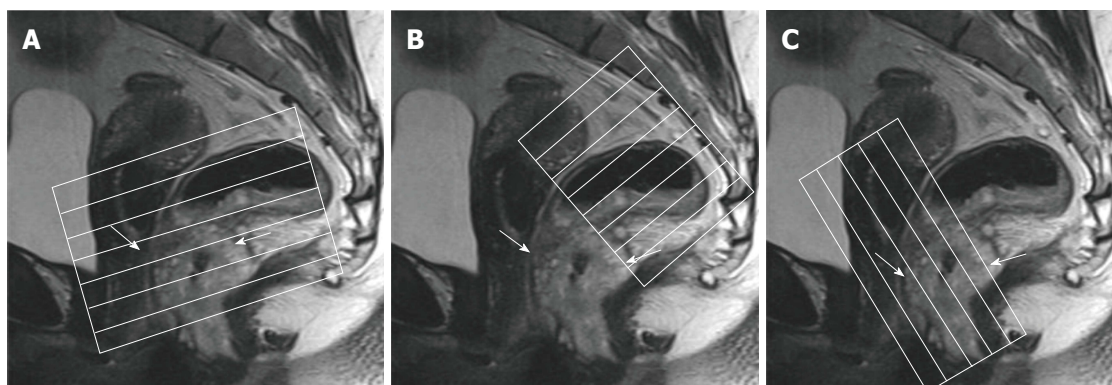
Magnetic resonance imaging planes. T2-weighted sagittal images are used to determine the longitudinal tumor axis in order to angle the axial and coronal planes. A: Oblique axial plane is obtained perpendicular to the rectal wall at the level of the rectal mass; B: Oblique axial plane is angled perpendicular to the pelvic floor, used to cover lymph node drainage territory; C: Coronal plane is angled parallel to the anal canal for imaging of low rectal tumors. Rectal tumor is indicated by arrows.
